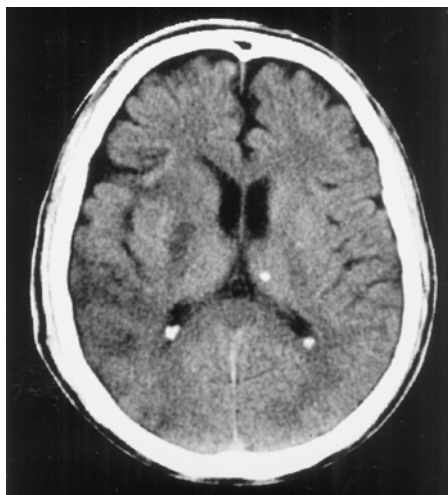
A computed tomography scan of the brain showed left cerebral infarction.
